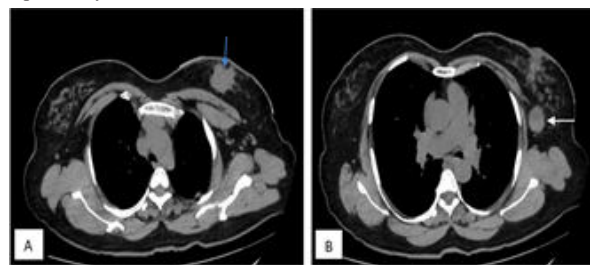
Axial CT sections of the thorax showing - A: A well-defined lobulated hypodense lesion in the upper inner quadrant of left breast (Blue arrow). The lesion shows spiculated margins. B: Enlarged left axillary lymph node (White arrow).
